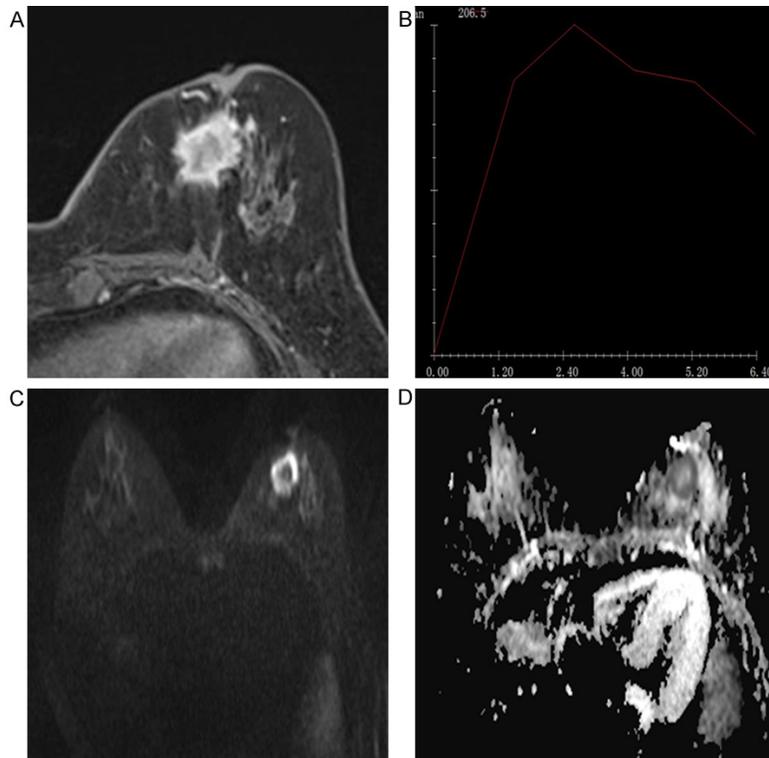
MRI findings for a 30-year-old woman with invasive ductal carcinoma in the left breast. A. The lesion showed irregular shape with peripheral and centripetal enhancement, spiculated margin, blooming sign and nipple inversion. B. The time-intensity curve showed a washout pattern. C. The lesion margin showed high signal in the diffusion-weighted image. D. The lesion margin showed low signal in the apparent diffusion coefficient map; the coefficient was $0.872 \times 10^{-3} \text{ mm}^2/\text{s}$. The identification value for this lesion (see Methods) was 5.792.
